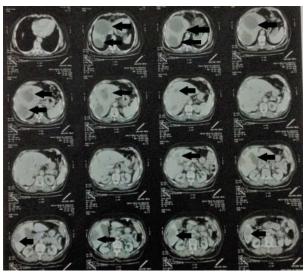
Computed tomography of the chest and abdomen. Arrows: multiple nodular images, suggesting metastatic process.
